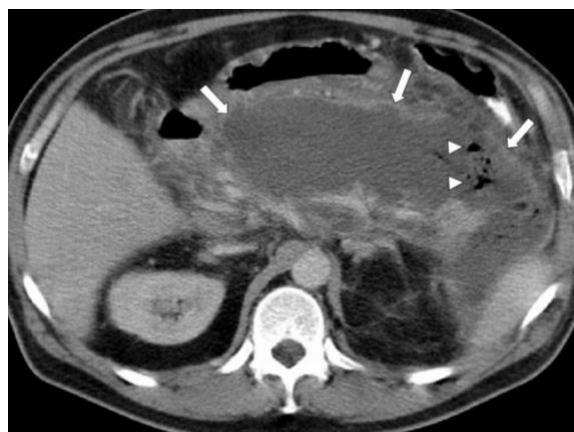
Contrast-enhanced computed tomography of a patient with acute pancreatitis 36 days after onset of symptoms. The body and tail of the pancreas are largely non-enhancing. Adjacent to the pancreatic bed is a large collection with predominately fluid-like attenuation (white arrows). Because of the gas bubbles (arrowheads), some would call this a 'pancreatic abscess' but others would call it 'infected pancreatic necrosis'
